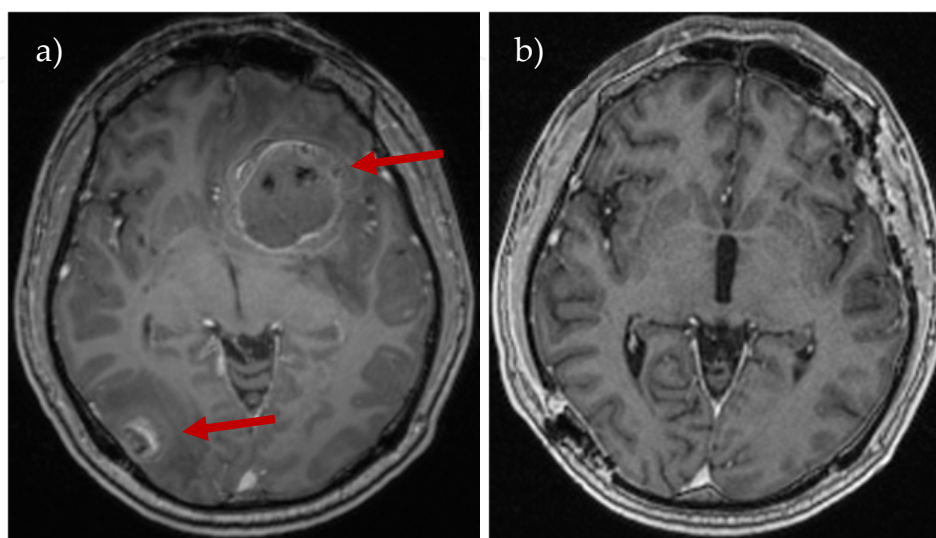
Pre-operative CT scan with multiple melanoma metastases. Brain metastases are indicated with red arrows (a). Post surgical CT scan (b).
